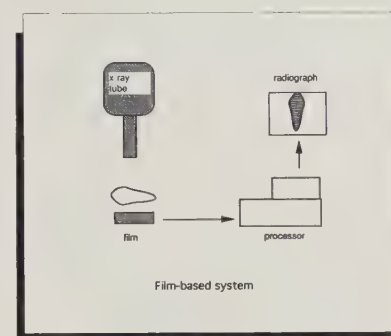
A conventional film-based system. This should need no explanation. Hard copy or the radiograph is available for interpretation in 4.5 to 7.0 minutes!
